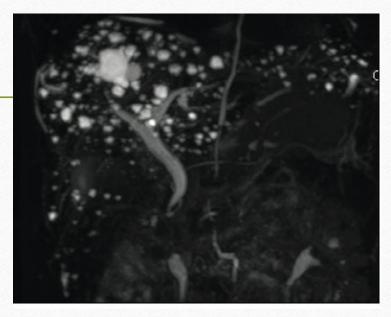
(a) Coronal T2-weighted MR image; (b) MRCP coronal projection, showing bile duct hamartomas in the liver of a young healthy woman.
